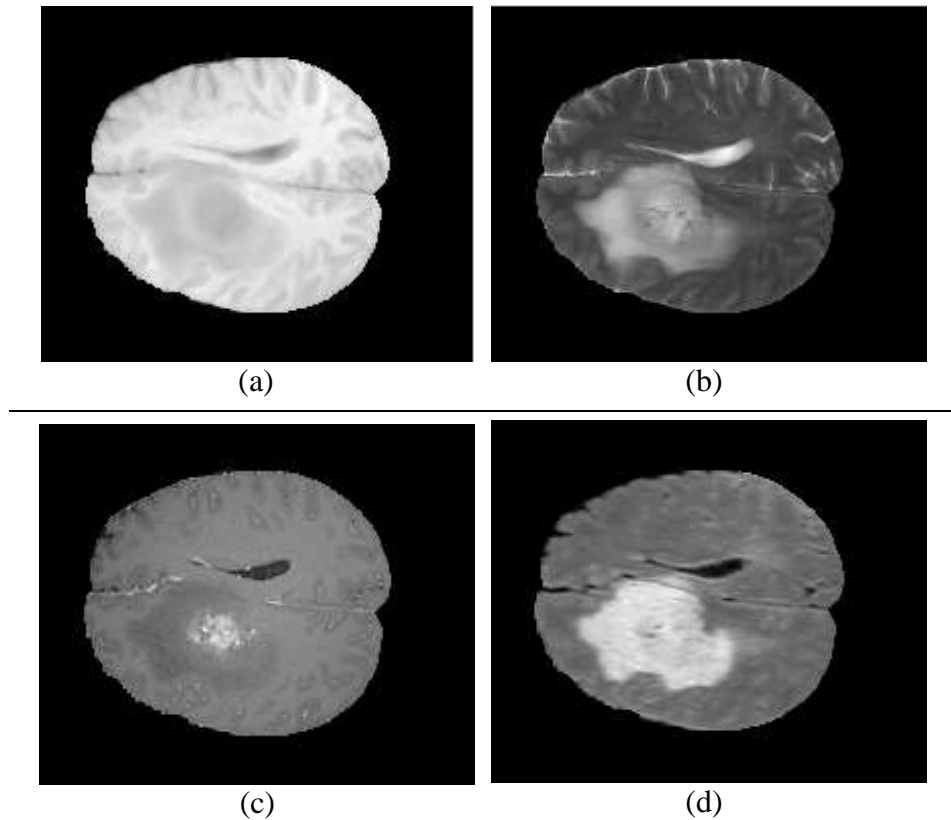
Multi-modality scans of a subject: (a) T1, (b) T2, (c) T1C, (d) FLAIR
